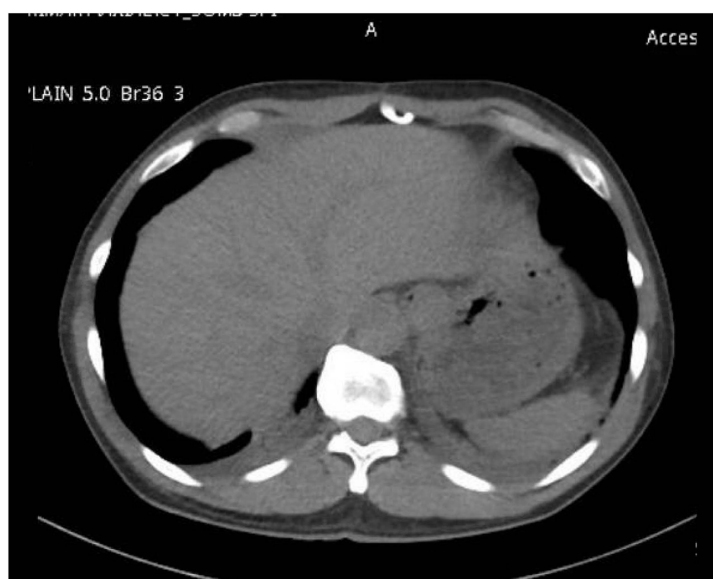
CT-KUB only finding was mild pleural effusion noted mainly at posterior segment.
